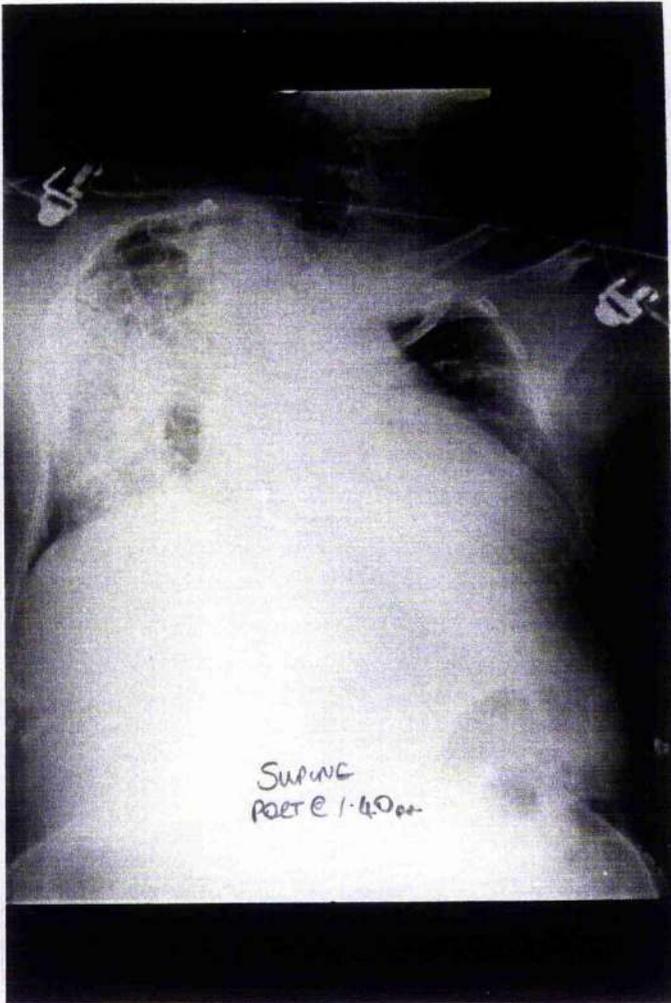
Chest radiograph of patient with chest wall disease due to congenital scoliosis, detailing the severe mechanical deformity of the thoracic cage.
